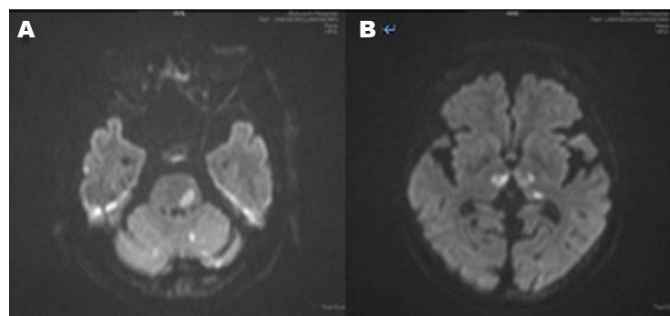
Head magnetic resonance images of a 72-year-old man showing (A) infarction of the brainstem and cerebellum and (B) bilateral thalamus.
